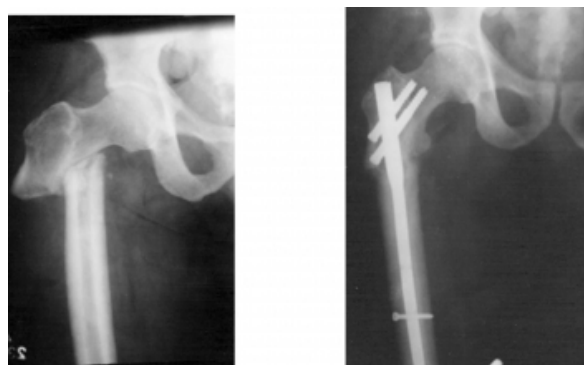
(a) Preoperative x-rays of non united Subtrochanteric fracture
